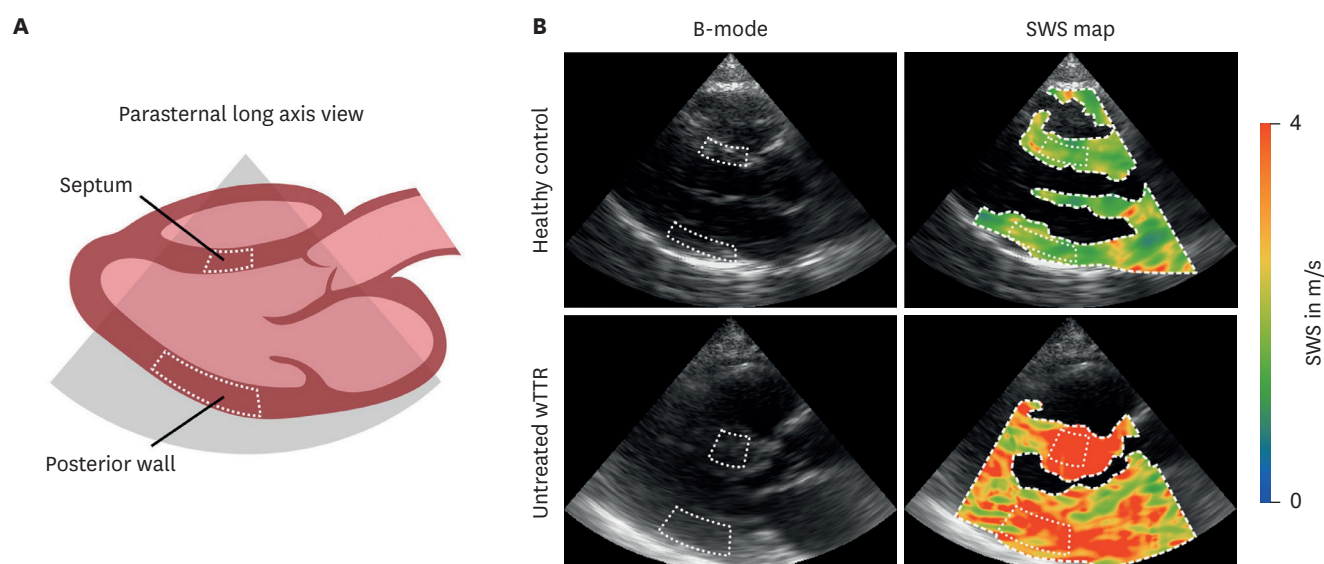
Example of cardiac time-harmonic elastography. (A) Anatomical overview of the measurements performed in the parasternal long-axis view. (B) Representative B-mode images and SWS maps of a healthy control subject and a hypertrophic cardiomyopathy patient. Regions of interest are demarcated by white dotted lines. Regions of interest of the septum and posterior wall were manually selected. A third region of interest (white dashed line in the SWS maps) was automatically identified to select a larger region of major portions of the myocardium visible in the image without any user interaction (adapted from Meyer et al.⁵⁾). SWS = shear wave speed; wTTR = wild-type transthyretin amyloidosis.
